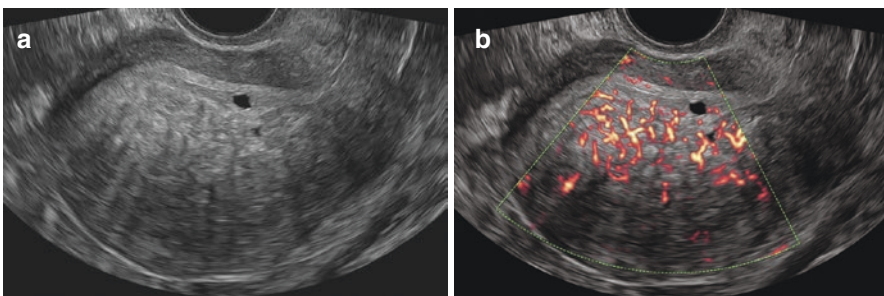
(a, b) Ultrasound images of diffuse adenomyosis of the posterior uterine wall involving JZ and outer myometrium; note the hyperechoic striation and the cystic areas in the JZ. (b) Power Doppler image showing diffusely spread small vessels
